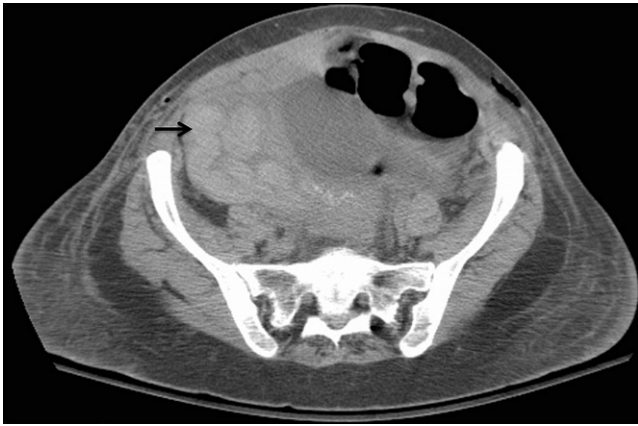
Right ovarian vein thrombosis in a 35-year-old patient after caesarean section and subtotal hysterectomy 7 days earlier, with ecchymosis and tachycardia. Axial computed tomography (which was performed without contrast to evaluate for hematoma because the patient's hematocrit level had decreased), demonstrating a markedly enlarged and tortuous thrombosed right ovarian vein (black arrow).
